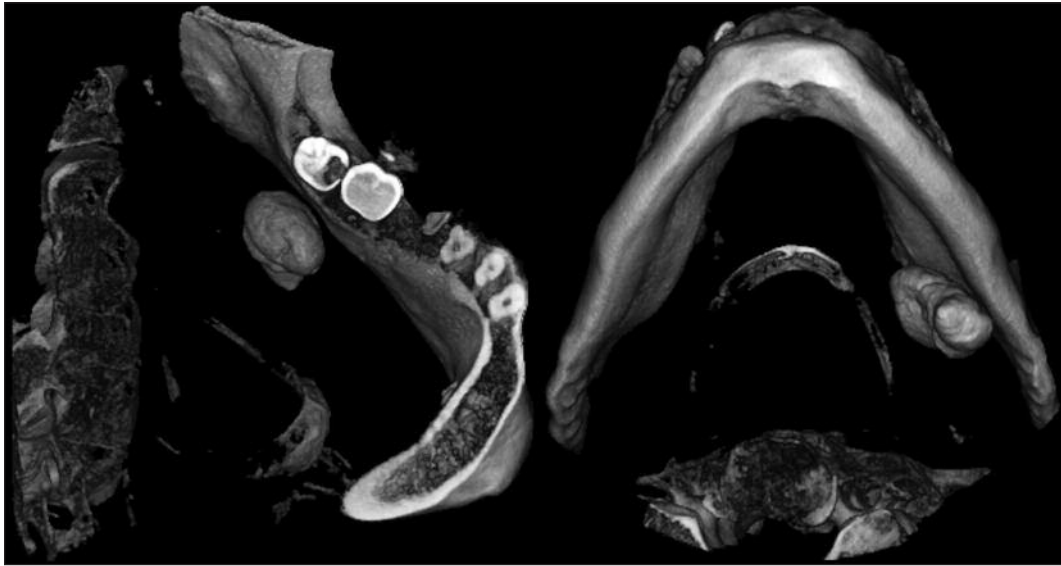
Three-dimensional reconstructed cone beam computed tomographic images from different aspects showing submandibular megalith.
